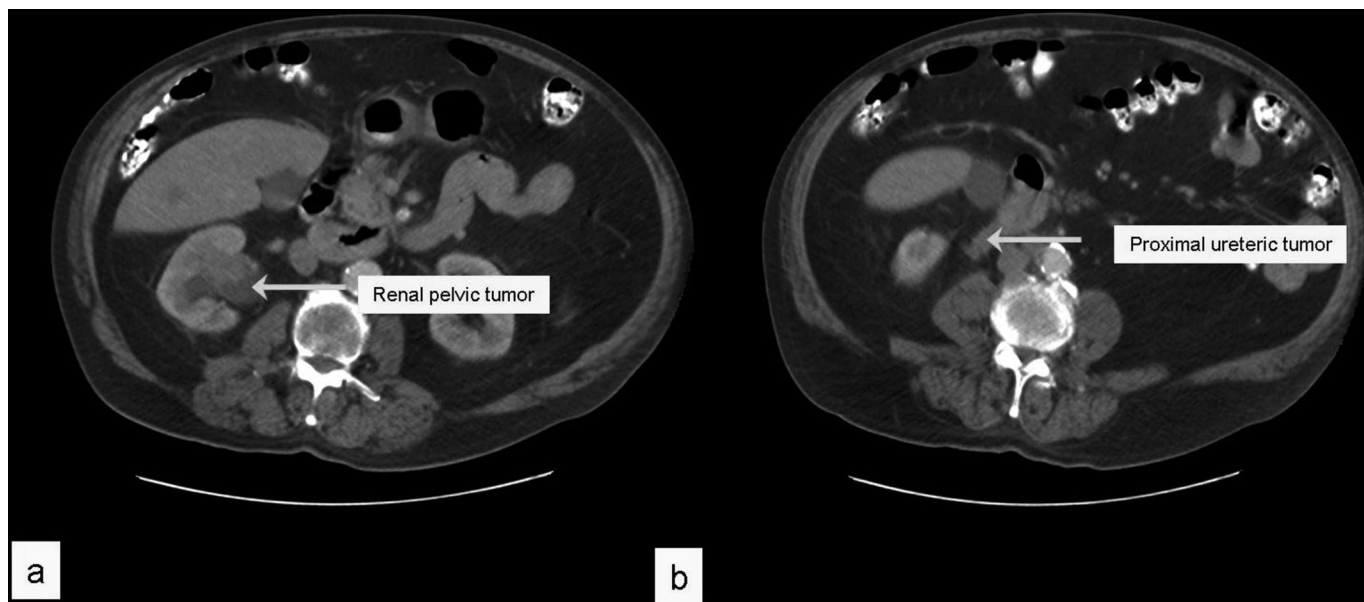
CT scan showing (a) mass in the right renal pelvis and (b) proximal ureteral abnormality in close proximity to the duodenum.
